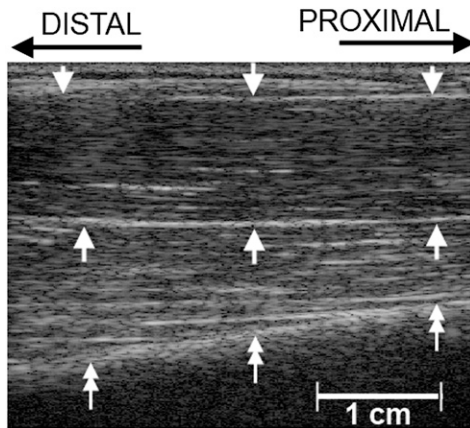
Sonogram of the upper arm with transducer oriented along the muscle fibres. The upper and lower boundaries of the biceps brachii are denoted by single arrows. Double arrows indicate the humerus. The area between the humerus and the lower boundary of the biceps brachii is the brachialis muscle and has not been included in this study.
